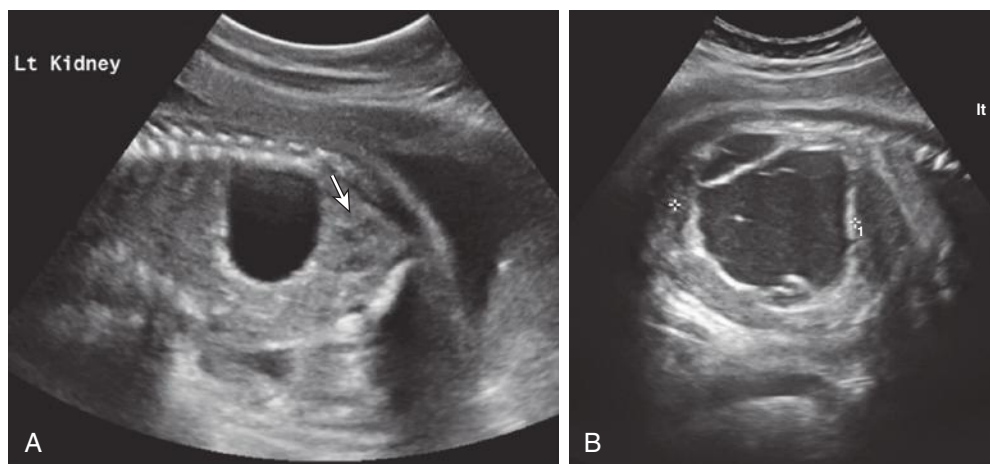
Adrenal cyst. A, Sagittal image of the left (Lt) fetal kidney (*arrow*) demonstrating a large cyst in the adrenal gland superior to the kidney at 27 weeks' gestation. B, The same fetus at 34 weeks' gestation, demonstrating interval evolution of the cyst. (Courtesy Department of Obstetrics and Gynecology, Yale University School of Medicine, New Haven, CT.)
